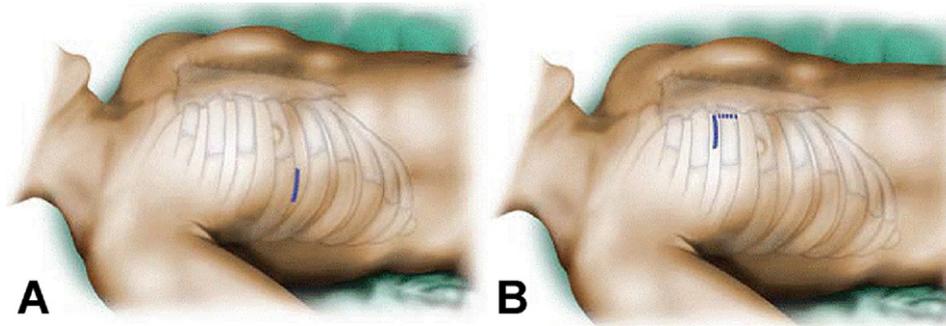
(A) For mitral valve procedures, a 4 to 5 cm skin incision is made in the right fourth to fifth intercostal space medial to the anterior axillary line. (B) For aortic valve procedures, a 4 to 5 cm transverse parasternal incision is made over the right second to third intercostal space and the second or third costochondral cartilage is transected.
